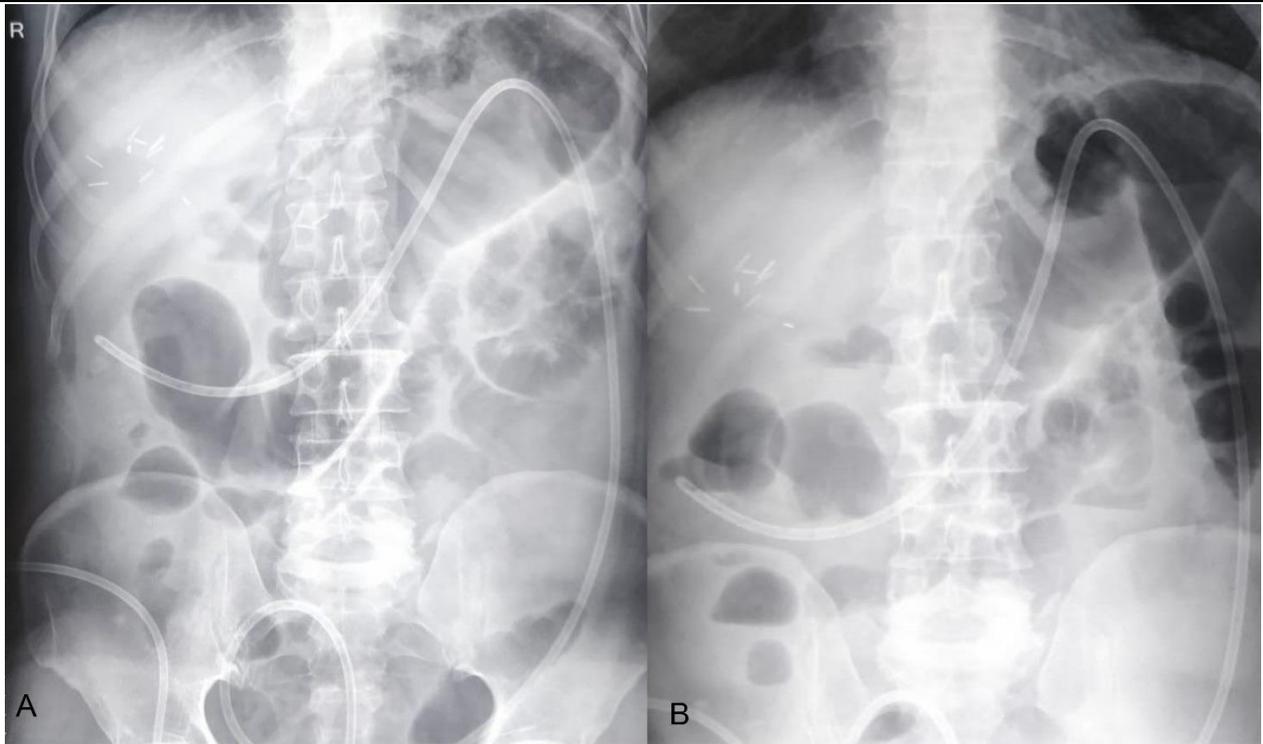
Abdominal X-rays showing markedly dilated colonic loops.
